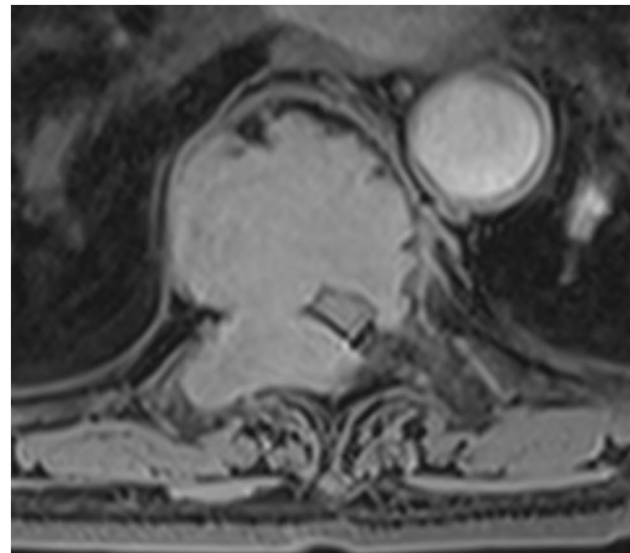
An axial post-gadolinium T1-weighted image of the thoracic spine in an elderly female demonstrating a homogeneously enhancing mass at T8 with pathology consistent with a plasma cell neoplasm
